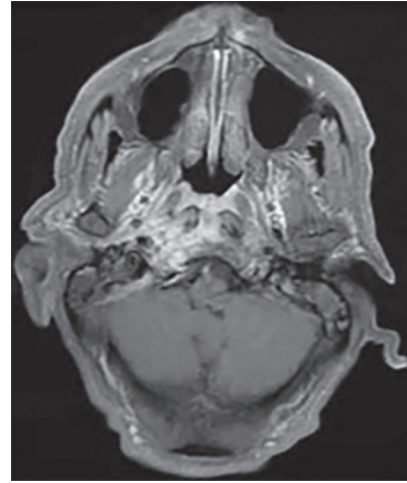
Magnetic resonance imaging (MRI) T1 with gadolinium showing an ill-defined lesion with contrast enhancement of the nasopharynx
